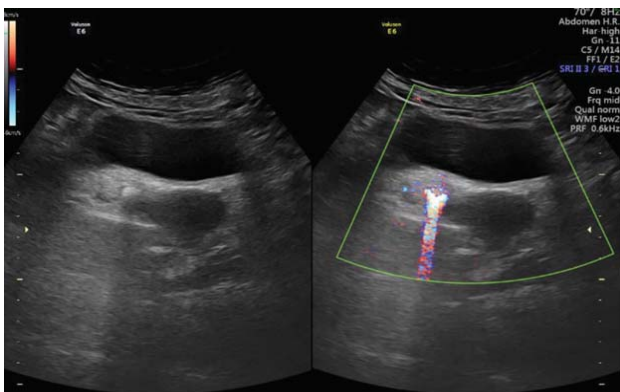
Grey and color Doppler ultrasound of ultrasound showing small echogenic focus with posterior acoustic shadowing at right vesico-ureteric junction consistent with small calculus demonstrating color comet tail artifact on Doppler ultrasound.
